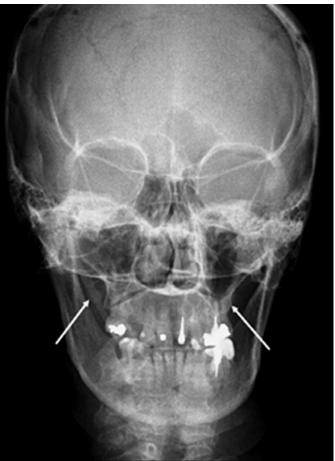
Arrows indicate an elongated styloid process in the posteroanterior radiograph.
